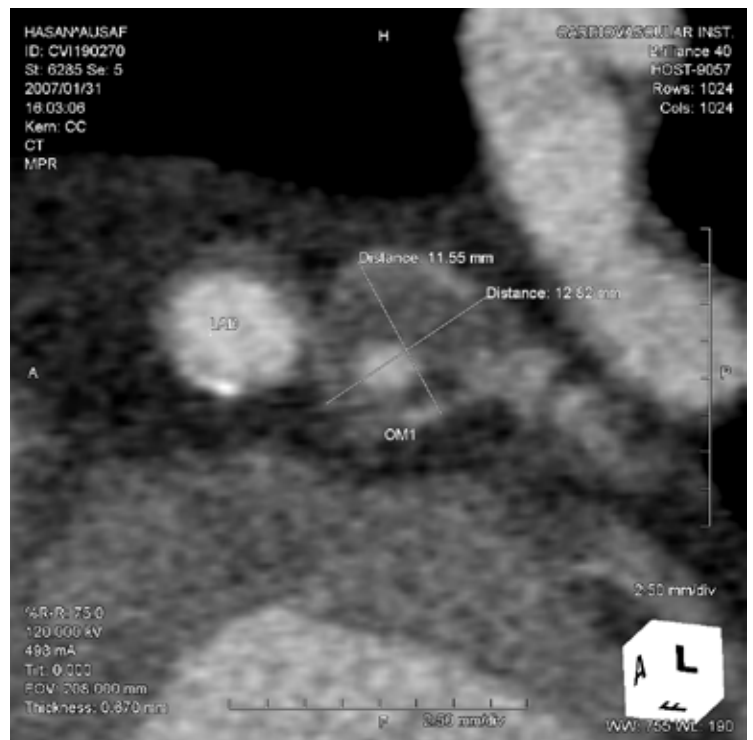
CT Multi-Planar Reformat with slice thickness 0.67 mm short axis of the OM-1 giant aneurysm with circumferential thrombus.
